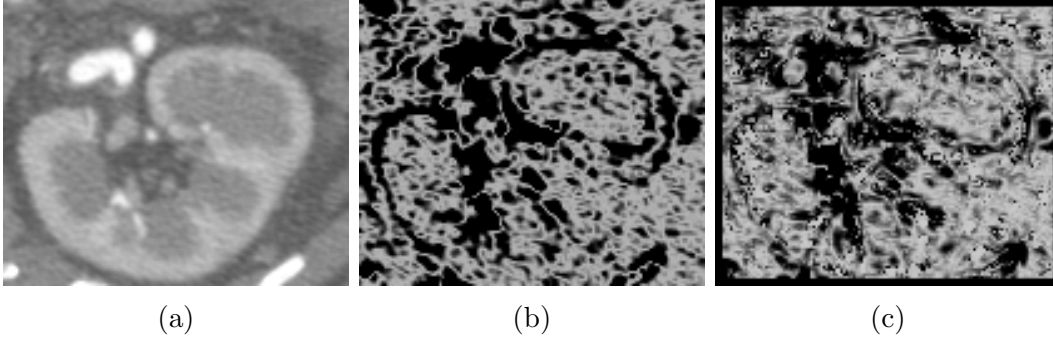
Dissimilarity maps. (a) One slice of original CT volume. (b) Conventional intensity-based dissimilarity map. (c) The proposed Hessian-based dissimilarity map.
